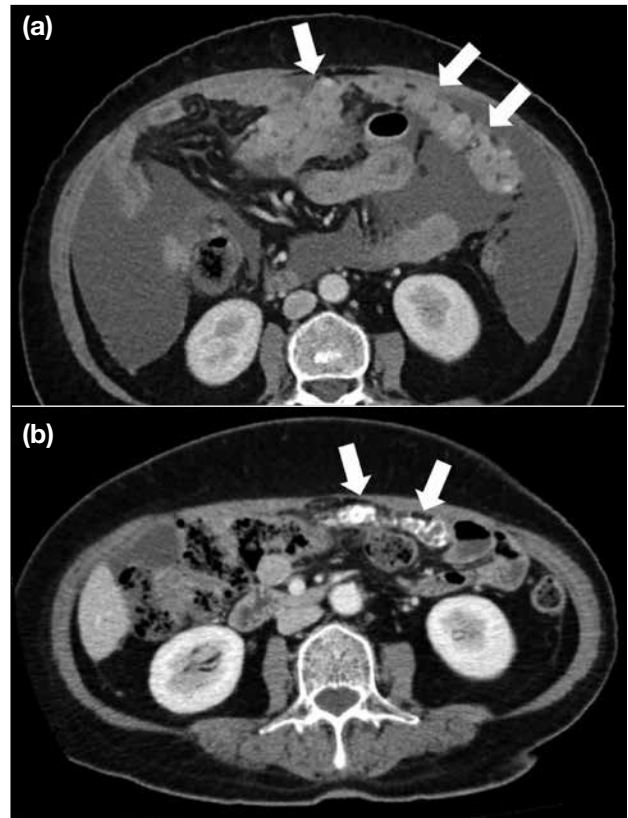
(a) Staging computed tomography (CT) image showing extensive omental deposits (arrows). (b) Follow-up CT after neoadjuvant chemotherapy showing interval shrinkage of omental deposits (arrows). Development of calcifications at the omental deposits is suggestive of post-treatment changes.
